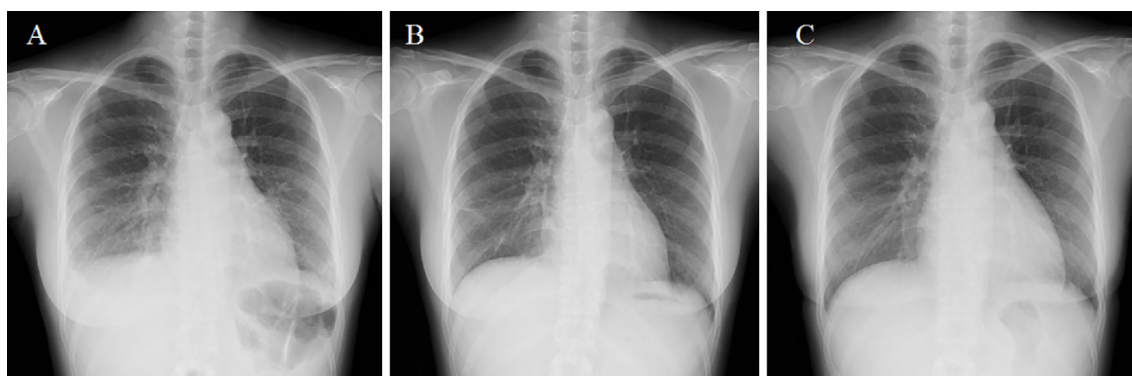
Chronological changes in chest radiography. (A) Chest radiography findings on admission. There was pleural effusion in the right lung. (B) The pleural effusion disappeared eight days after admission. (C) Enlargement of the central pulmonary arteries and cardiomegaly four months after admission.
